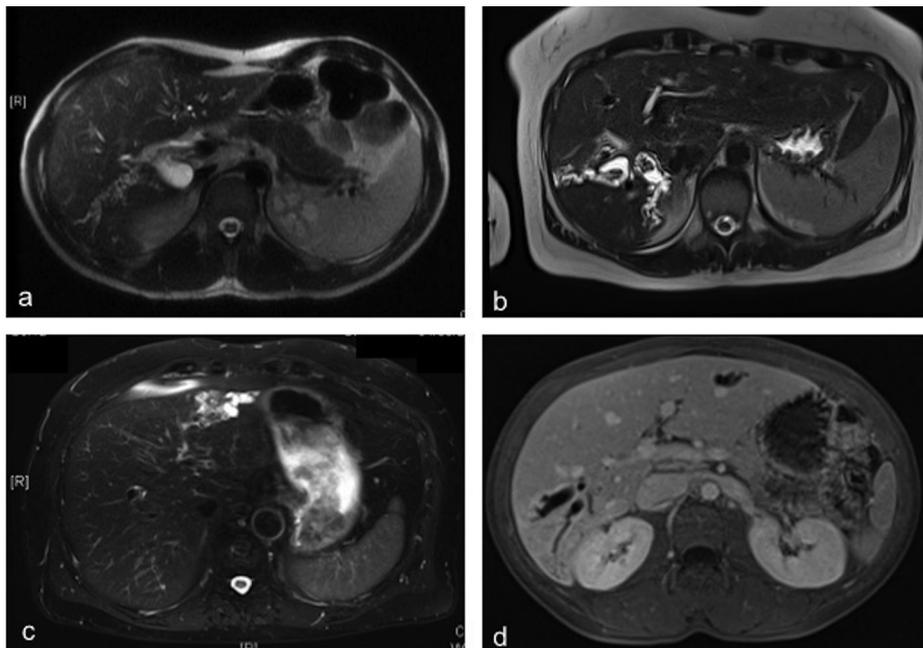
Intrahepatic lithiasis in MRI; a: T2 Haste sequence: posterolateral sectoral microlithiasis. A 20-year-old male patient. Satisfactory evolution with ursodeoxycholic acid; b: T2 Haste sequence: posterolateral sectoral lithiasis with macro-lithiasis and biliary tract dilatation; a 43-year-old female patient. Refusal of hepatectomy and evolution to cholangiocarcinoma; c: T2 Haste sequence: lithiasis of segment III with atrophy of this segment. A 56-year-old male patient. Partial effectiveness of ursodeoxycholic acid. Left lobectomy; d: sequence T1 Fat Sat with injection of gadolinium during portal phase: lithiasis of the right posterolateral sector and segment III. A 41-year-old female patient. Partial effectiveness of ursodeoxycholic acid. Right posterolateral sectoriectomy.
